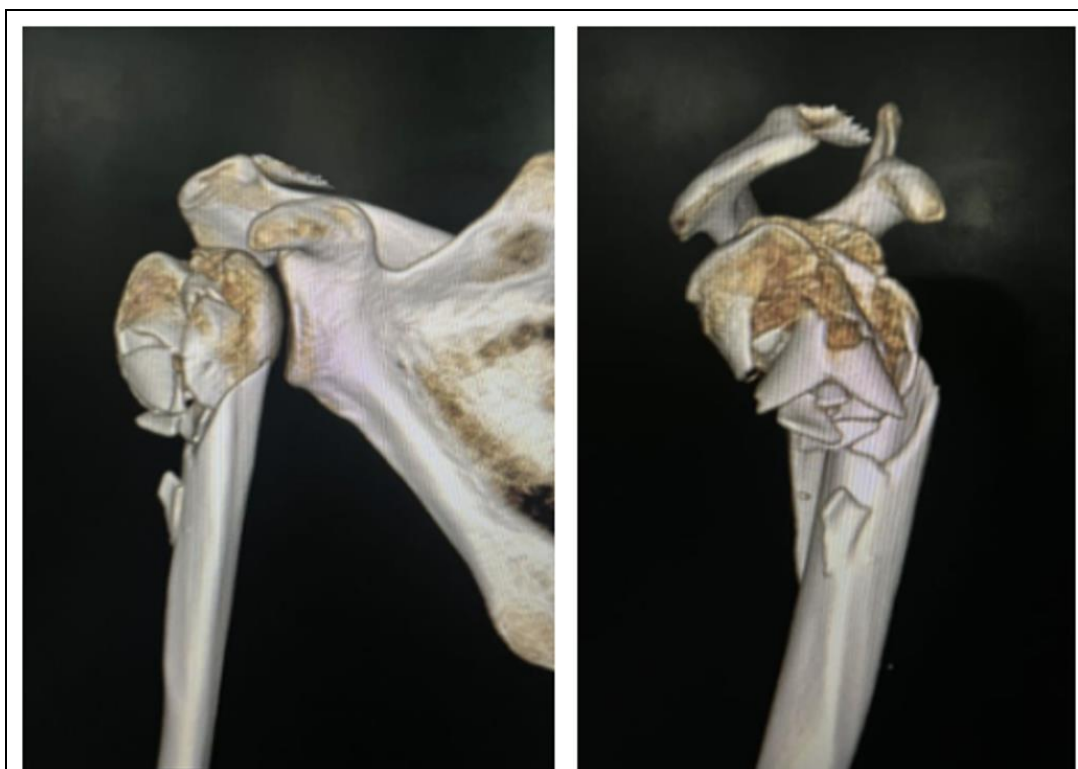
Three-dimensional CT reconstruction demonstrating fracture configuration, displacement of the proximal fragments, and medial column comminution, facilitating preoperative surgical planning.
